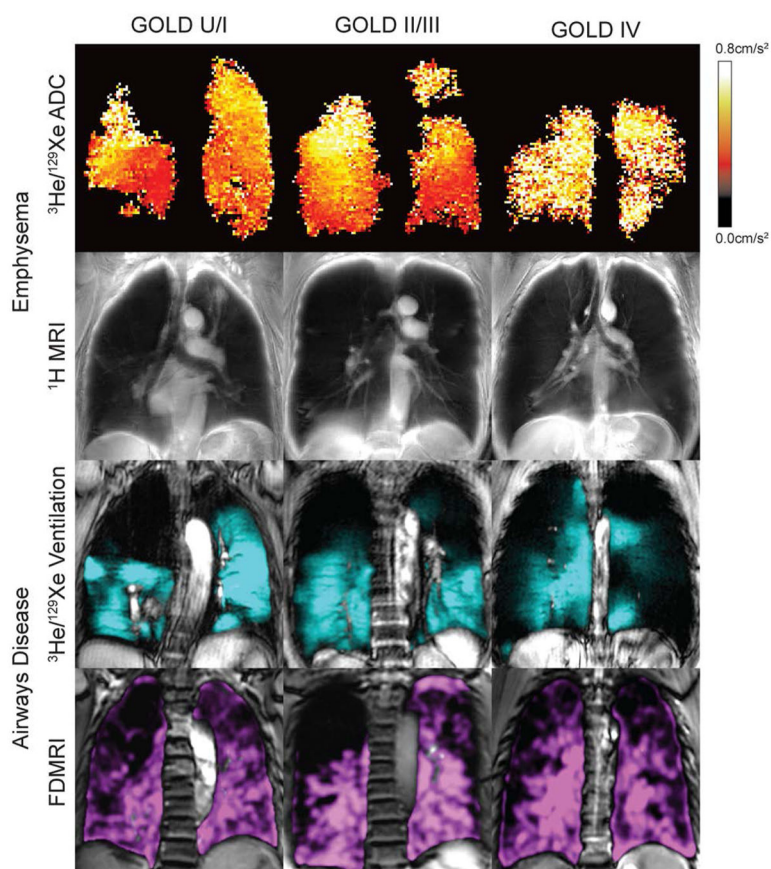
MRI measurements of COPD for different GOLD stages including: emphysema (ADC, ^1H MRI signal intensity), and ventilation (^3He MRI and FDMRI).
